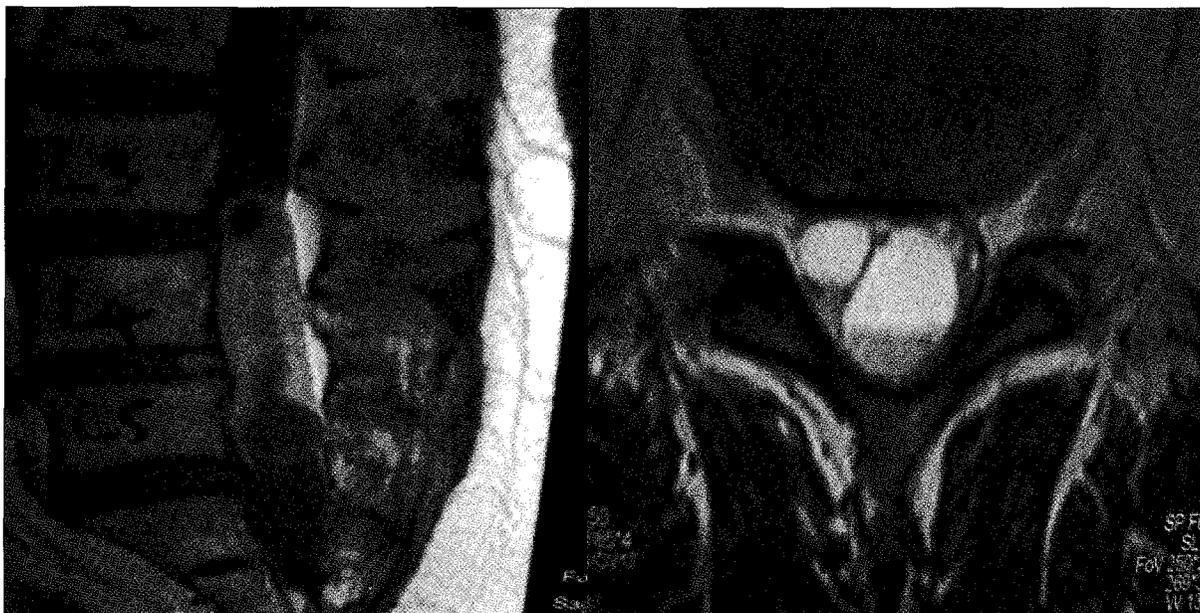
MRI showing an intradural lesion at L3-L5 vertebral level which was heterogeneously enhanced with contrast (A). On axial view of T2WI, this lesion appears cystic in nature as evidenced by multiple fluid levels (B). The spinal nerves are displaced laterally.
